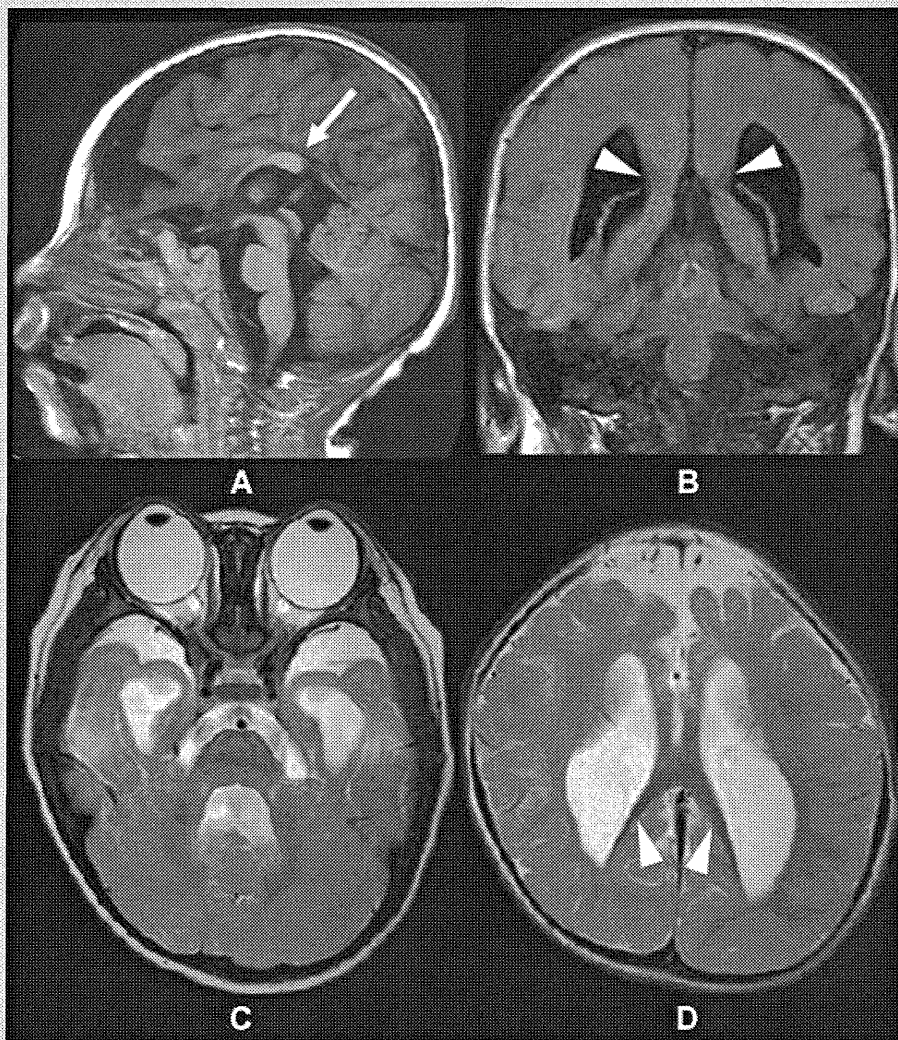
MRI findings of the patient. A: Sagittal T1-weighted image. The corpus callosum is markedly hypoplastic [arrow], whereas the cingulate gyrus is preserved. The volume of the brainstem is proportionally reduced compared to that of the cerebral white matter. B: Coronal fluid-attenuated inversion-recovery image. Longitudinal fibers, such as the bundle of Probst, are detected in the mesial margins of the lateral ventricles [arrow heads]. C, D: Axial T2-weighted images. A marked dilatation of the lateral ventricles is noted along with a marked reduction in the volume of cerebral white matter, particularly in the frontal and anterior temporal lobes. Longitudinal fibers, such as the bundle of Probst, are present in the mesial wall of the posterior part of the lateral ventricles [D, arrow heads].
